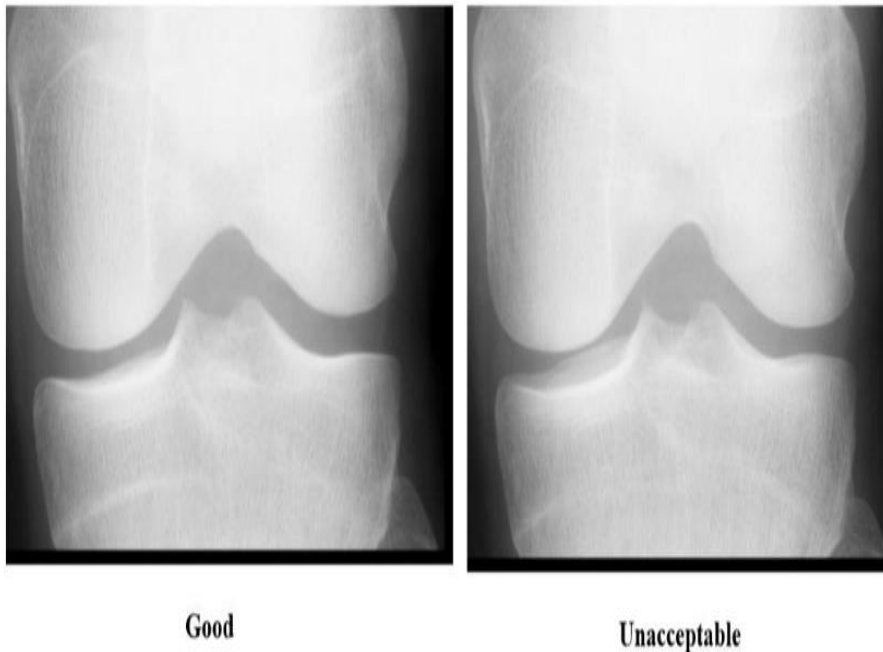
Xray AP view of Knee - a) Correct and b) Incorrect
